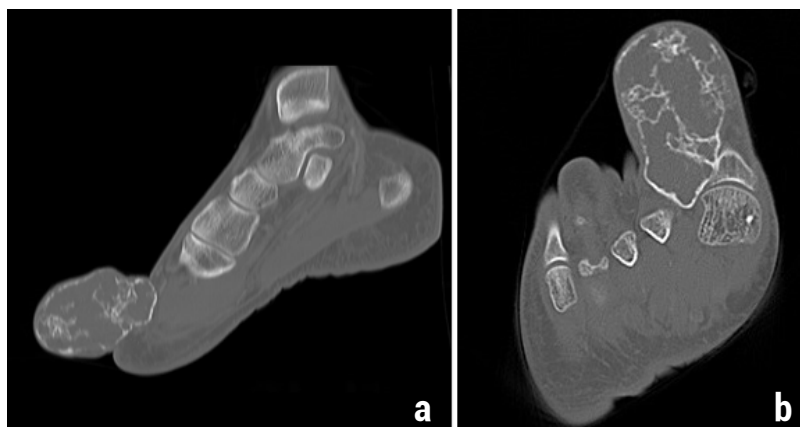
Expansile, lytic, multiloculated lesion around distal phalanx in computed tomography scan. a) antero-posterior view, b) lateral view
